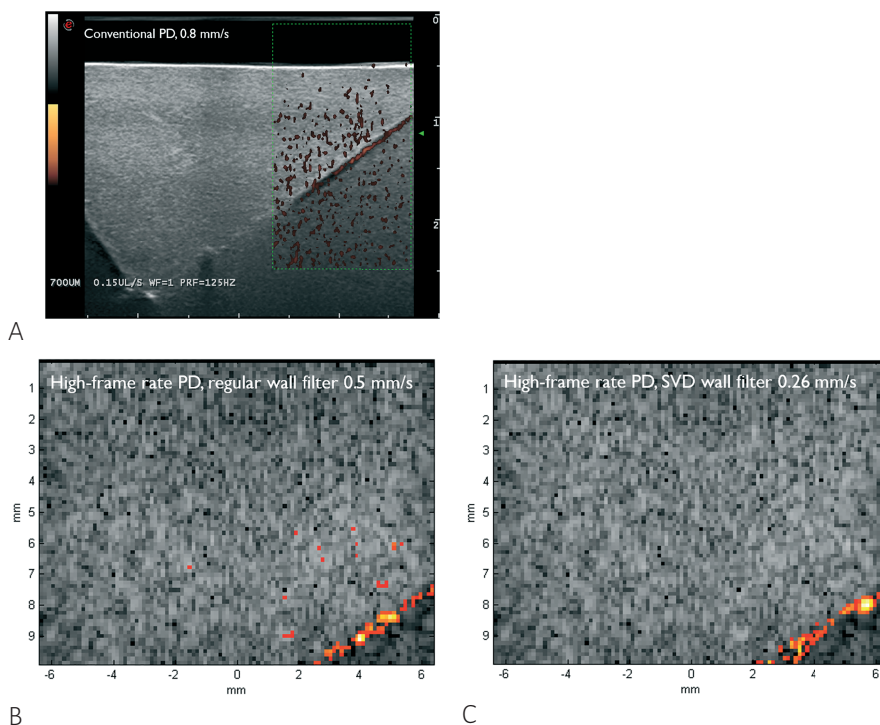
PD images obtained in the 700 μm vessel at the lowest detected velocity with the respective machines and wall filtering; (A.) Conventional PD ultrasound, lowest wall filter, and $V_{\text{peak}} = 0.8$ mm/s ; (B.) High-frame rate Doppler, conventional wall filter, and $V_{\text{peak}} = 0.5$ mm/s; (C.) High-frame rate Doppler, tissue filter based on Singular Value Decomposition (SVD), and $V_{\text{peak}} = 0.26$ mm/s. (PD = power Doppler).
